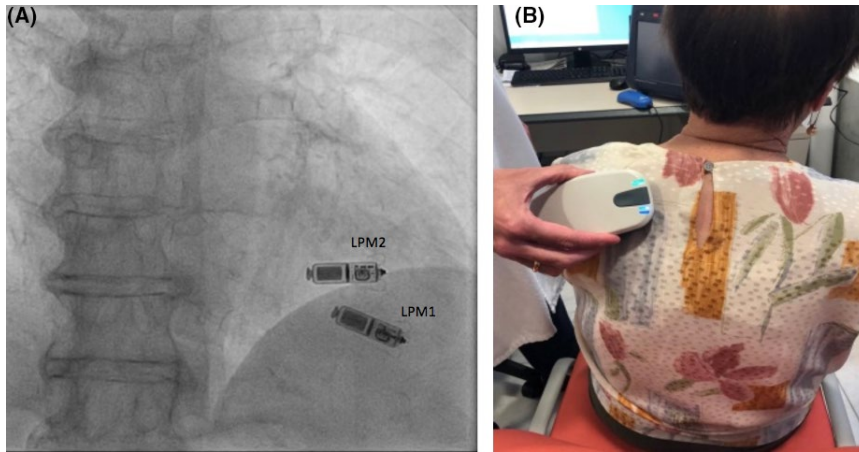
Panel A, posteroanterior chest X-ray imaging showing the implanted leadless pacemaker (LPM) devices. Panel B, green light on the transmitter head of in-home monitoring indicating data transmission
